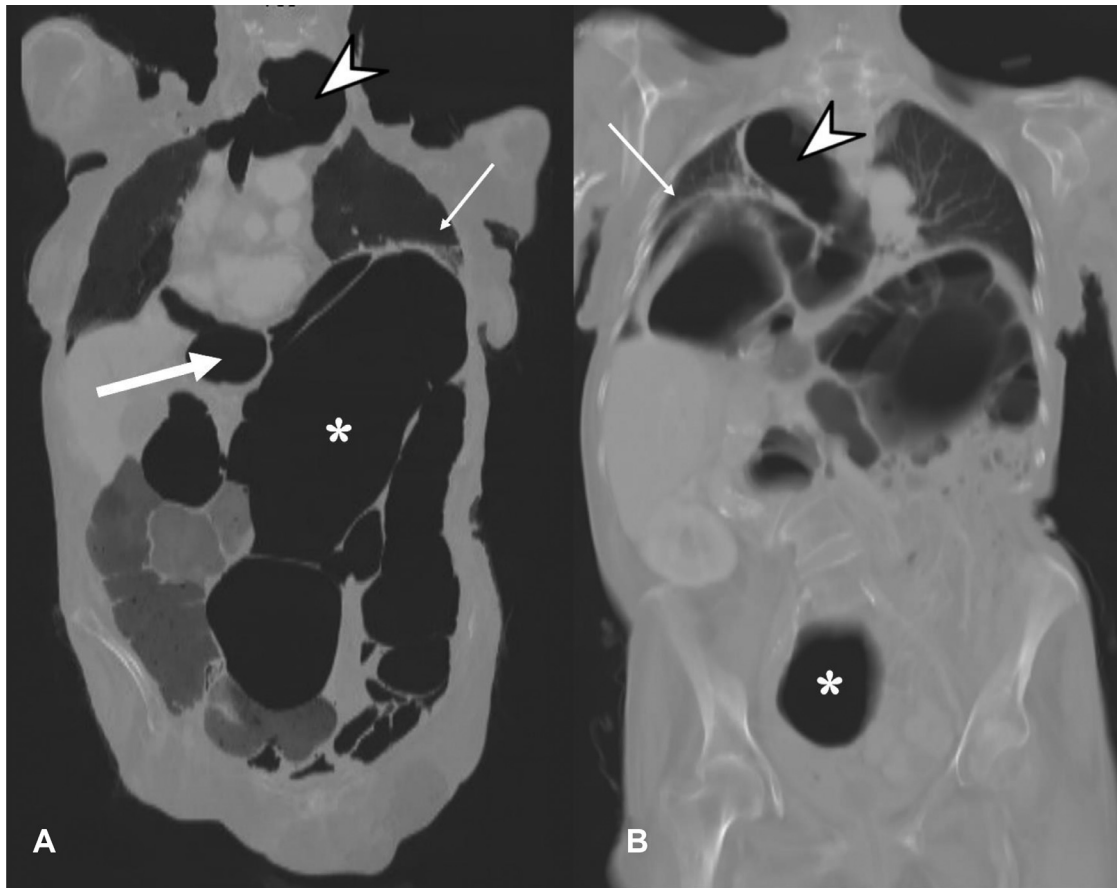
(A, B) Coronal contrast enhanced CT. Images obtained with Minimum-intensity projection (MinIP) reconstruction and visualized on lung window showing overall picture. In particular, it is possible to see sigmoid (asterisks in A, B), esophageal (arrowheads in A, B) and duodenal (thick arrow in A) dilatation; elevated hemidiaphragms with gastric rise (thin arrows in A, B) could also be seen. These elements taken together accounted for reduced lung expansibility and patient's shortness of breath. Additionally, an inverted "U" shape of the sigmoid colon can be seen in the left upper abdomen, which is a classic sign of sigmoid volvulus (asterisk in A).
